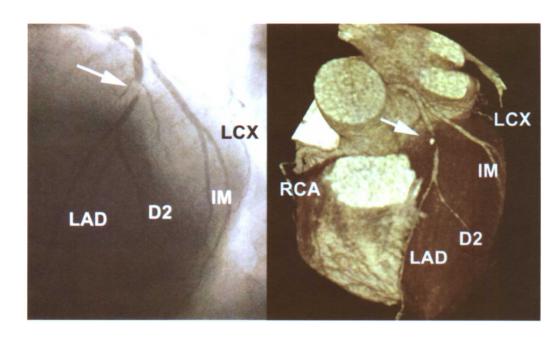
前降支中段,第一对角支远端冠状动脉狭窄的患者传统 CT 和 MSCT 冠状动脉显像(三维 容量显像)。MSCT中可以看见斑块的钙化成分。左回旋支(LCX),右冠状动脉(RCA),第二对角 支(D2),中间支(IM)也能看见
